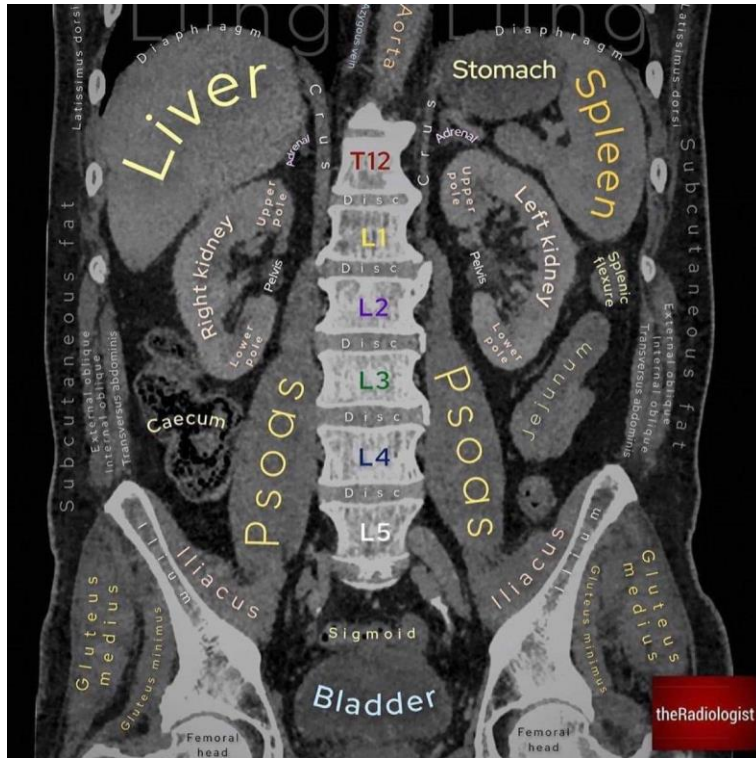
Normal liver CT
